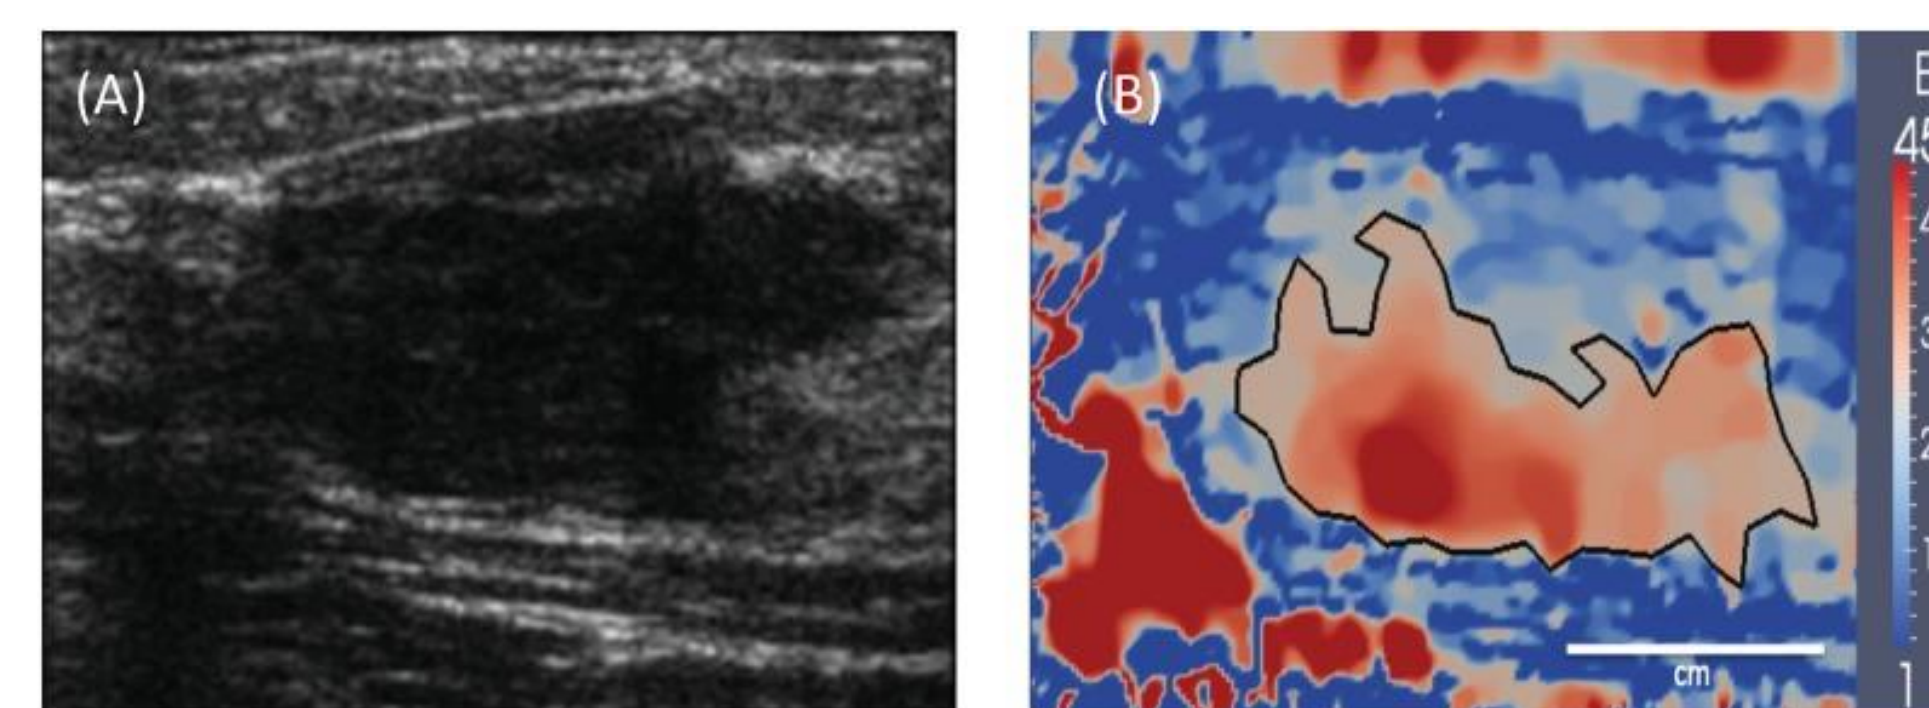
Ultrasound imaging of two heterogeneous fibroadenomas. Adapted from Liu et al.^[8]
